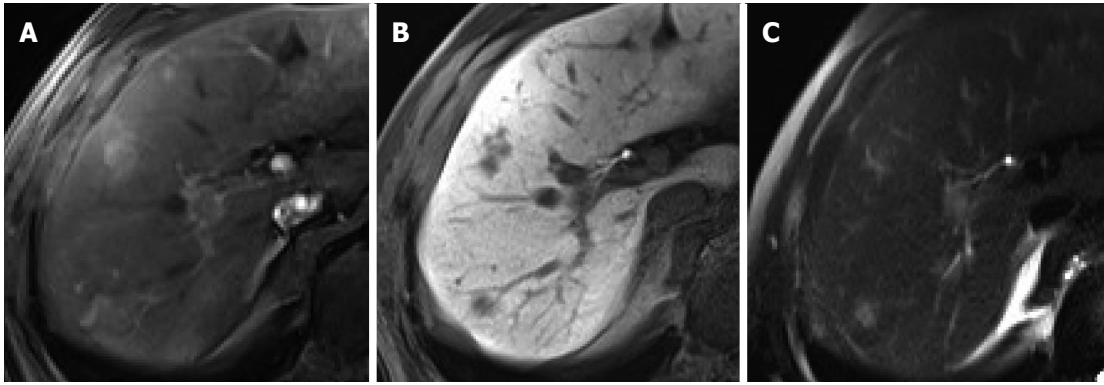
Focal eosinophilic infiltration in a 52-year-old man. A: Hepatic arterial phase of gadoxetic acid-enhanced MRI shows two irregular homogeneously enhancing nodular lesions in segments 7 and 8; B: Hepatobiliary phase shows low signal intensities with ill-defined margin and nonspherical shape; C: Heavily T2-weighted image shows smaller size of the lesions in S8, compared to (B).
